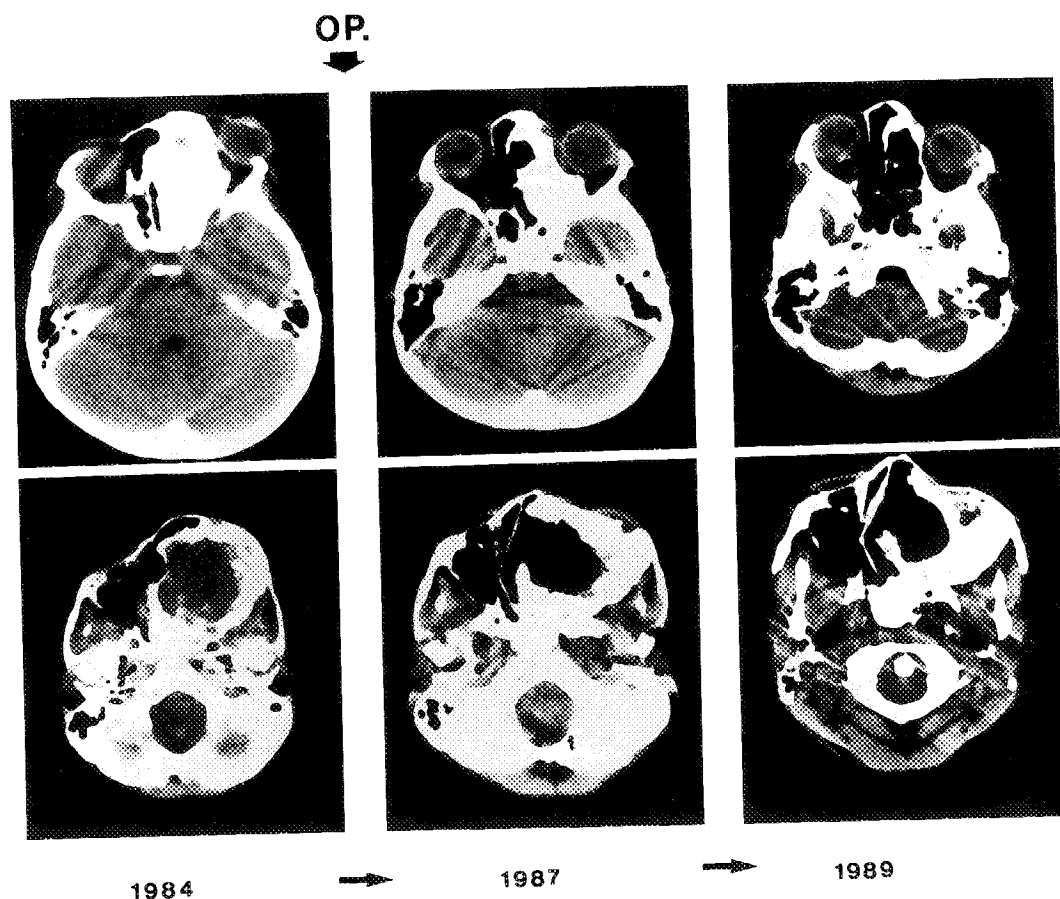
Computed tomographic scan at the level of the orbit and the maxilla. Note the involution of dysplasia, especially in the ethmoid cells and the orbit.
